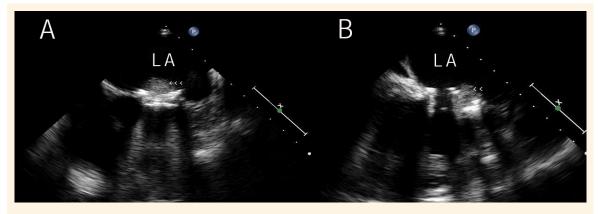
A & B: Transoesophageal echocardiograms showing (A) a large, soft clot over the mechanical prosthetic bileaflet mitral valve on the atrial side (arrowheads) and (B) a thrombus with the immobile leaflet of a mechanical prosthetic bileaflet mitral valve in a closed position (arrowheads). The other leaflet can be seen to be opening well. LA = left atrium.
